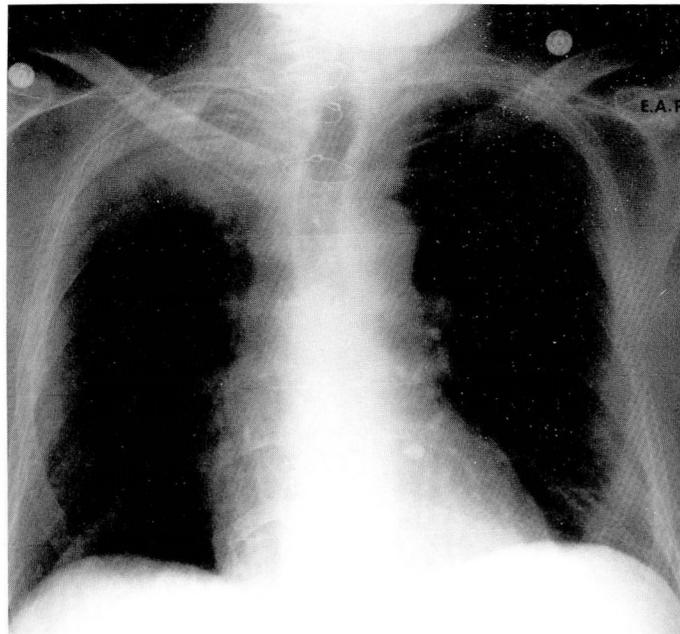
Chest radiograph showing the initial right upper lobe infiltrate.
